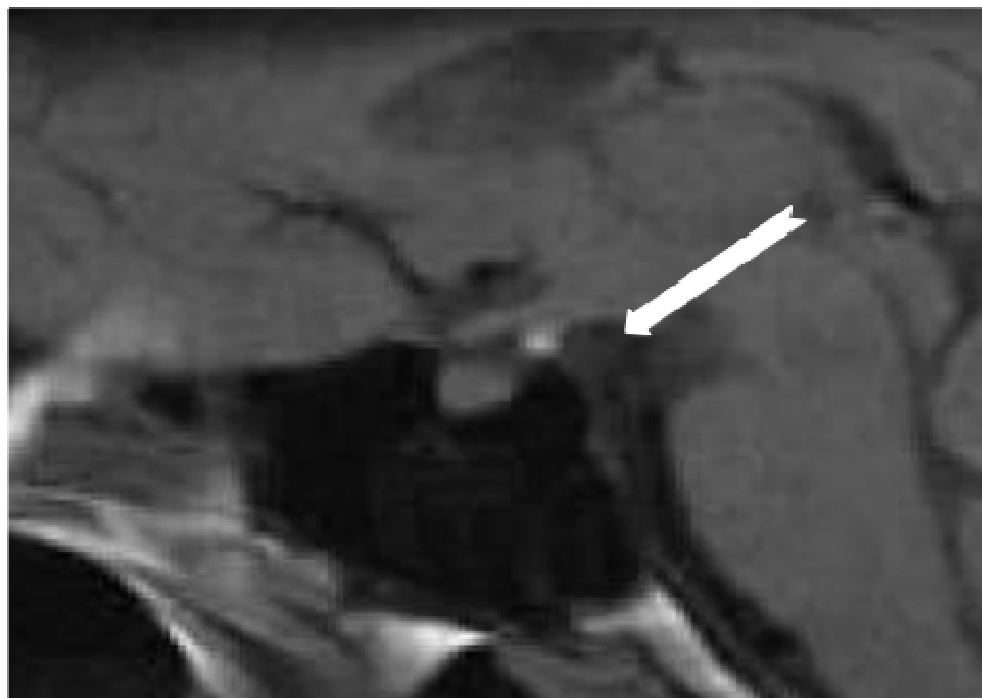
Magnetic Resonance Imaging (MRI), demonstrating hypoplastic anterior pituitary and ectopic posterior pituitary gland. (arrow)
